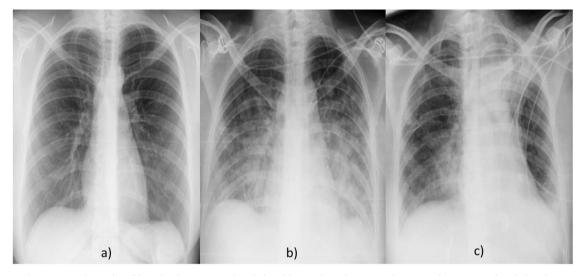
a) Chest X-ray on the 1st day of fever; b) Chest X-ray on the 4th day of fever and on admission to the ICU; c) Chest X ray on the 7th day of antimicrobial.
